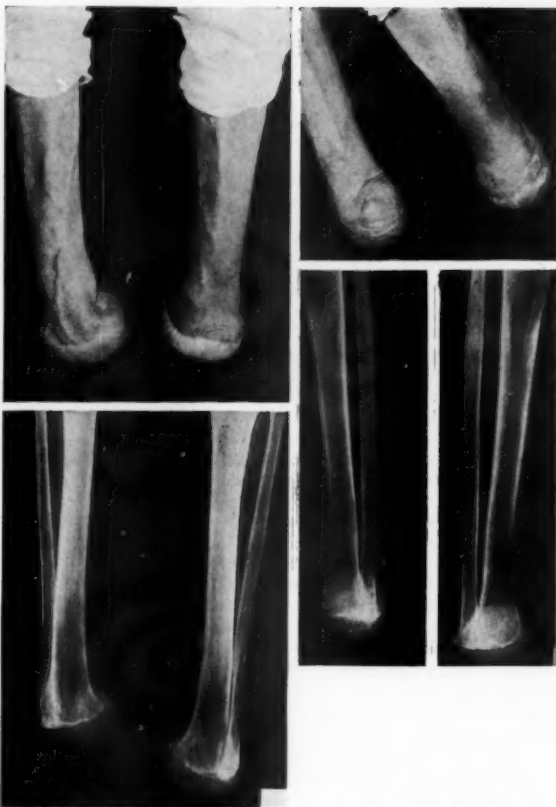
Case 11 (W. W.). Front and side views of bilateral Syme stumps. Right stump (viewer's left), after nine years; left stump (viewer's right), after six years. Corresponding x-rays show bony proliferation from subperiosteal dissection of the flaps.
